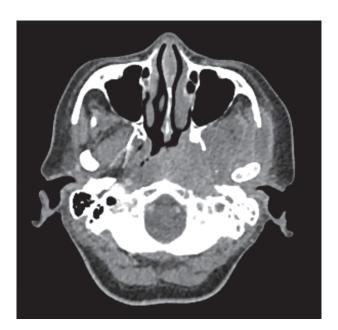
HRCT temporal, axial cuts showing abscesses in the left parapharyngeal extending to left fossa of rossenmuller, left masticator space and left temporomandibular joint.
